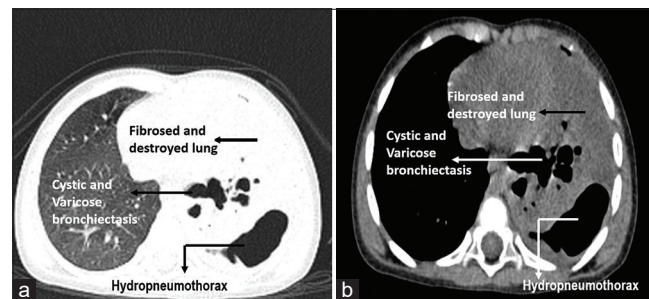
Noncontrast computed tomography thorax. (a) The lung window. (b) The mediastinal window. Each image showing hydropneumothorax, cystic and varicose bronchiectasis, and fibrosed and destroyed lung as marked with arrows
